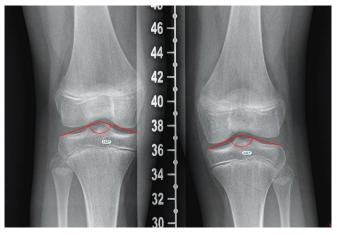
Radiograph of the knee showing the tibia roof angle
